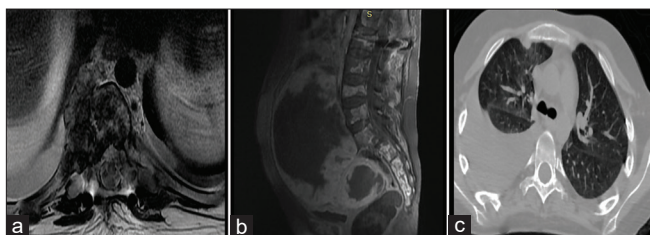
(a and b) spinal magnetic resonance imaging showing multiple metastatic lesions (spine and peritoneum) and mass recurrence at L1 level. (c) Chest CT-scan showing pulmonary effusion.
